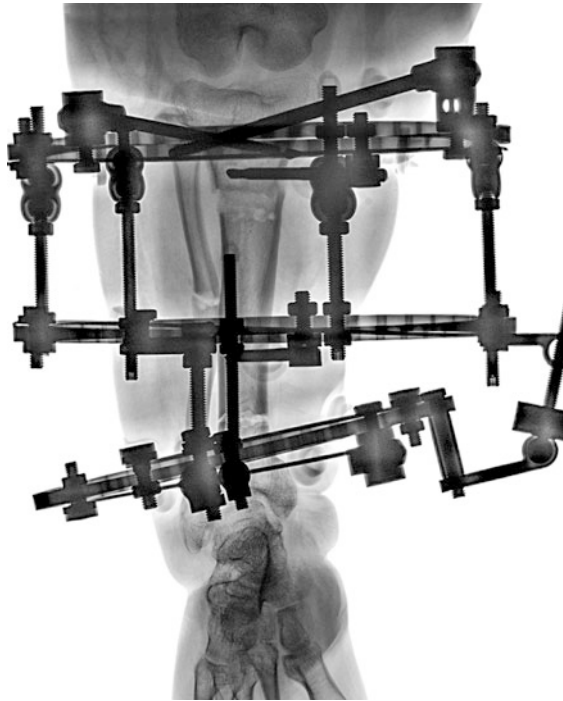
AP radiographs of the tibia after distal tibial osteotomy and midshaft fibular osteotomy for varus deformity correction. Note that two hinges and angular distractor between the proximal and middle rings were replaced with four lockable universal hinges attached to threaded rods providing compression. Also the proximal tibia and fibula were secured at this time with a half pin
